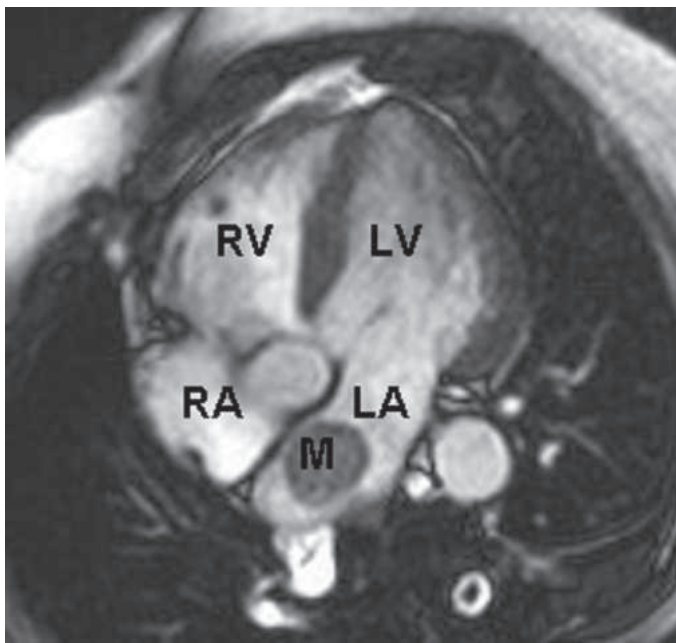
Cardiac magnetic resonance imaging demonstrating a rounded mass (M) within the left atrium (LA). Pathologic evaluation at the time of surgery revealed it to be an atrial myxoma. LV, left ventricle; RA, right atrium; RV, right ventricle.
